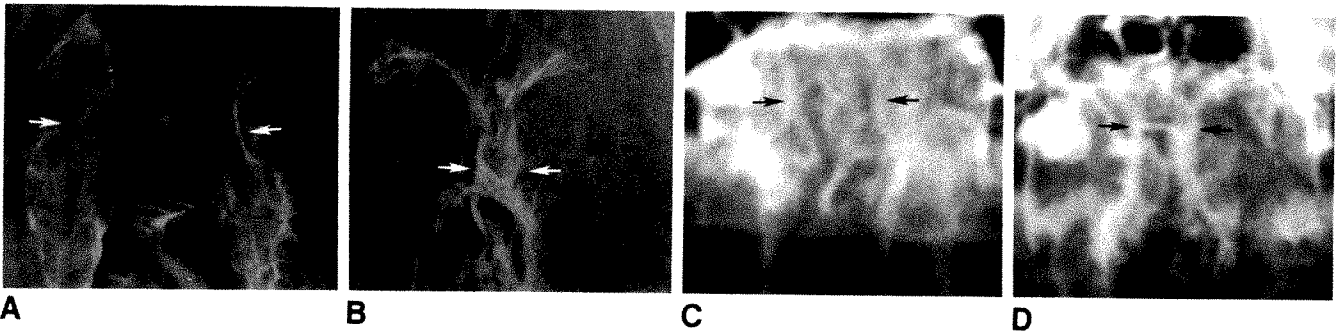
Radiographs of normal lateral pharyngeal walls, frontal projections.
